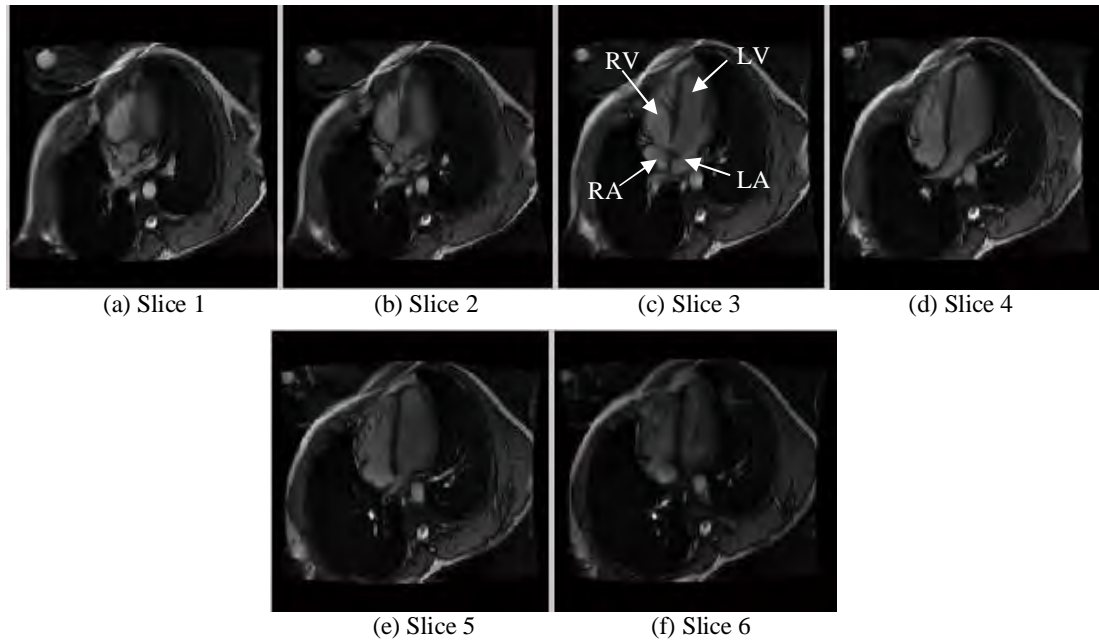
Examples of Cardiac MRI in Four Chamber View per slice. The left ventricle, left atrium, right ventricle and right atrium are visible.
